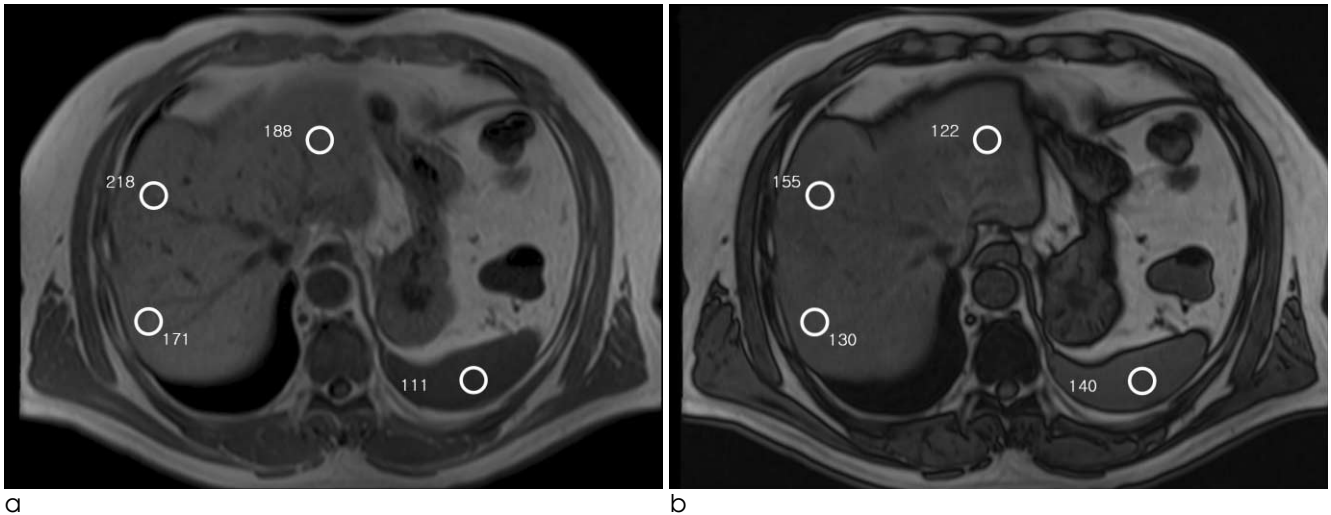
Chemical shift MRI of the liver in-phase (A) and out-of-phase in a 52-year-old man.
